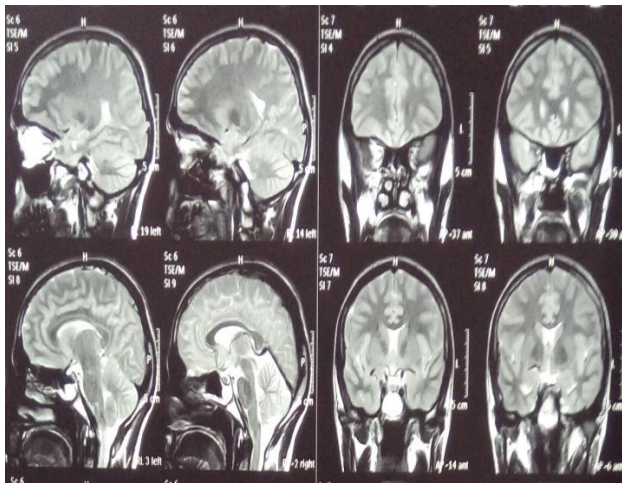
Normal MRI brain with contrast.
